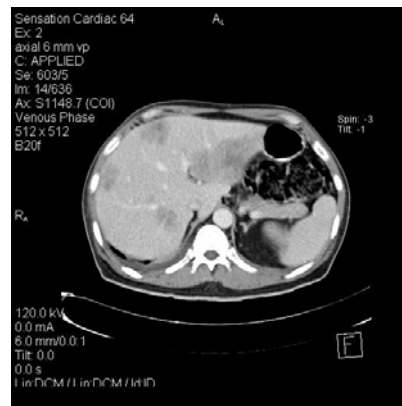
CT scan: multiple lesions in all segments of the liver
